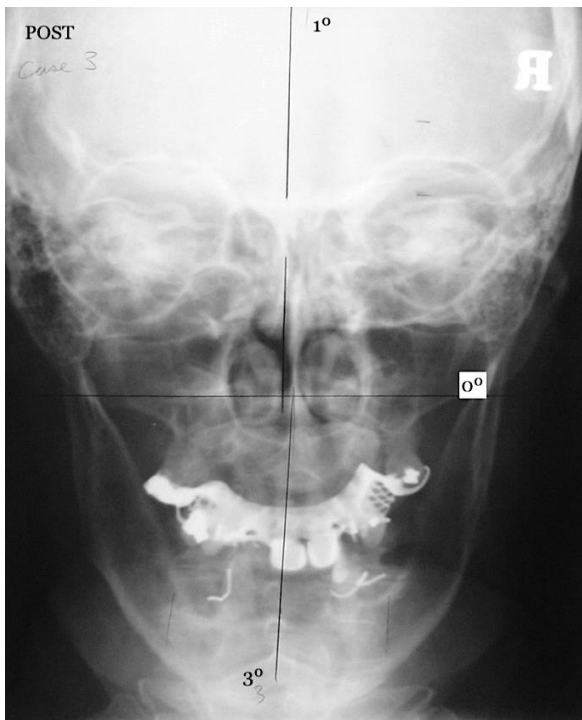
Lines drawn on post-adjustment radiograph for calculation of roentgenometric values
